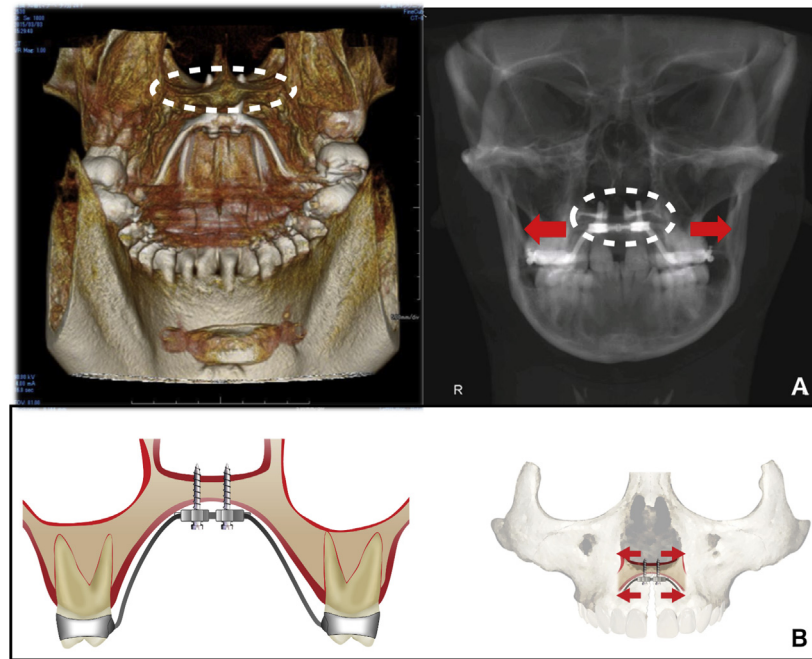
Patient 1: A, CBCT image showing placement of MSE. Bicortical engagement (*dotted circle*) of the miniscrews is essential in nonsurgical midfacial expansion; B, maxillary expansion with bicortical engagement MSE. Generally, an average of 2 mm soft tissue, 5-6 mm of bone contact, 2 mm of screw head contact, and a total of 9-11 mm of miniscrews are required for the force to be expressed in a parallel direction (*red*) with less strain.
